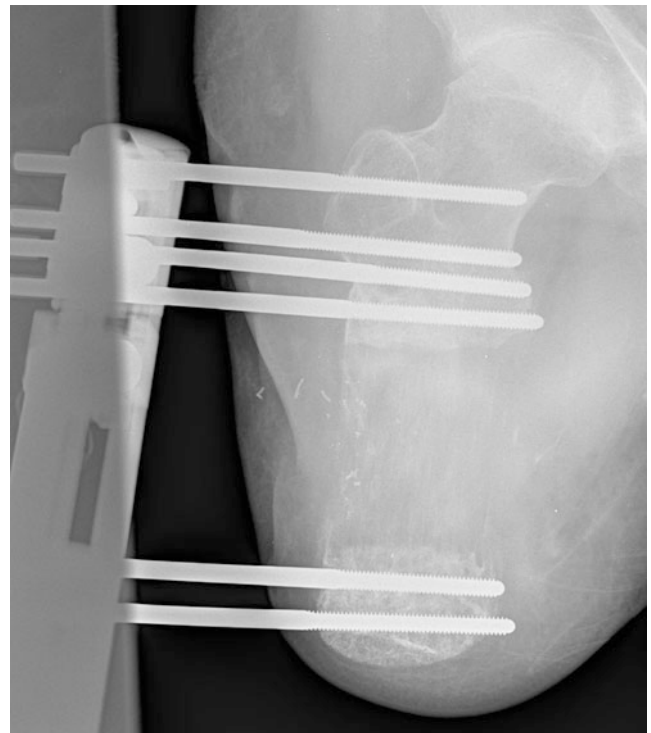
AP X-ray at the end of lengthening phase
